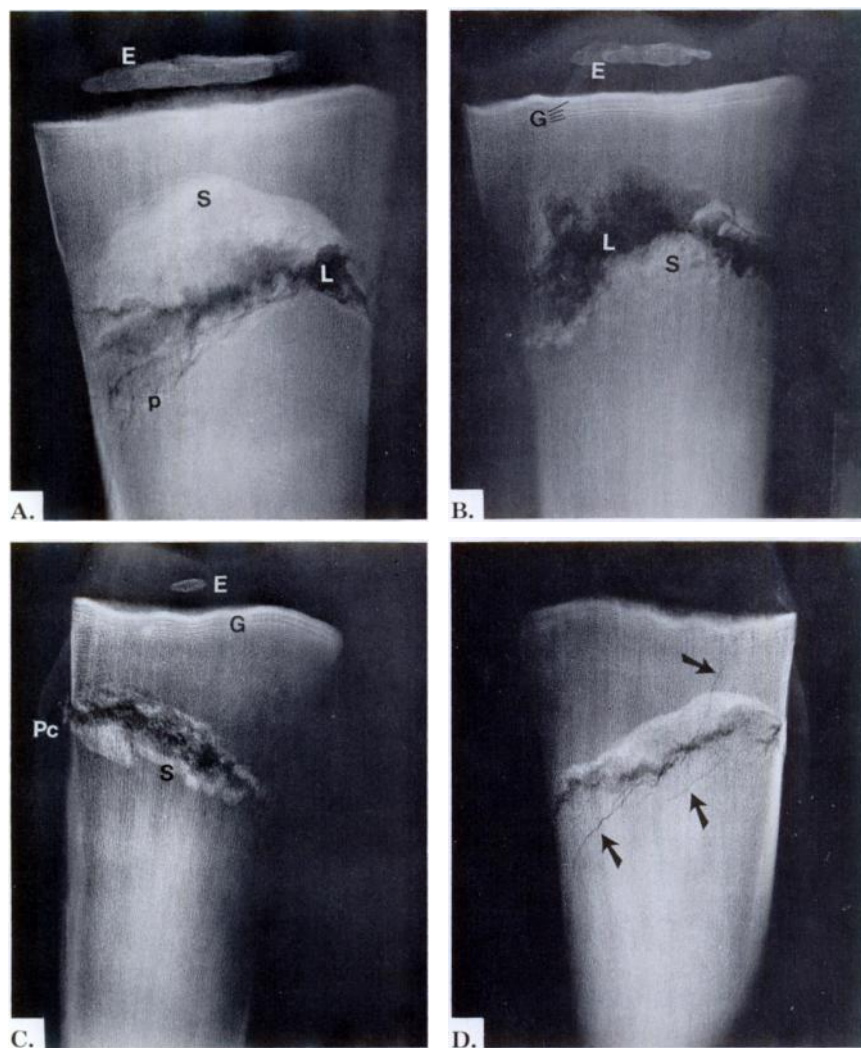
A. Roentgenogram of distal radius showing a lytic central area (L) and sclerosis (S) within the distal fragment. Additional fracture propagations (P) are evident in the proximal fragment. E — epiphyseal ossification center of distal radius. B. Ventral half of distal radius showing more extensive lytic (L) area, and sclerosis (S) in proximal side of fracture. Transversely oriented growth "arrest" lines (G) are evident across the distal metaphysis. These are thin except for the one closest to the physis. This particular band is thick and sclerotic and probably represents altered growth since the fracture. C, D. Dorsal and ventral halves of the distal ulna, showing variably lytic and sclerotic fracture, with some propagation (arrows) into proximal and distal fragments. Comparable growth arrest lines are also evident. A small region of subperiosteal callus (Pc) is evident.
